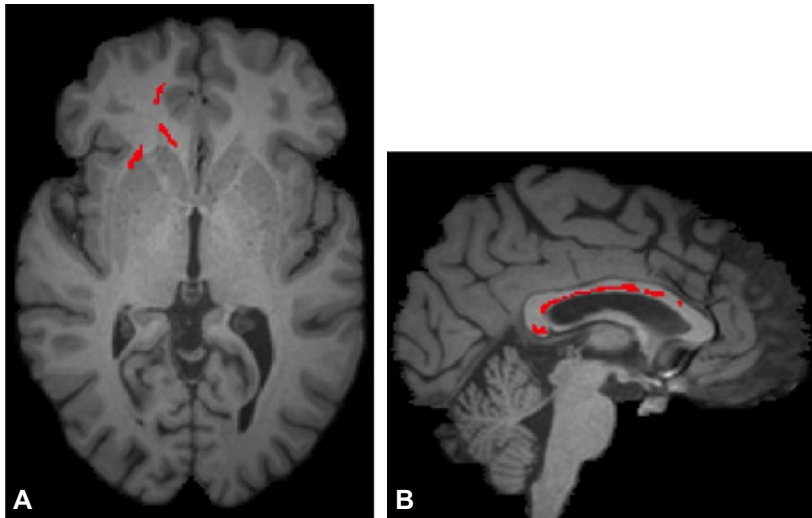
(A) Diffusion tensor imaging abnormalities in a patient with mild traumatic brain injury, overlaid on structural imaging. Clusters of abnormally low fractional anisotropy (red) are shown within the right frontal lobe on axial T1-weighted images (A) and in body and splenium of the corpus callosum on sagittal T1-weighted images (B) (Suri et al., 2015). These regions reflect microstructural changes not visible on conventional magnetic resonance imaging.
